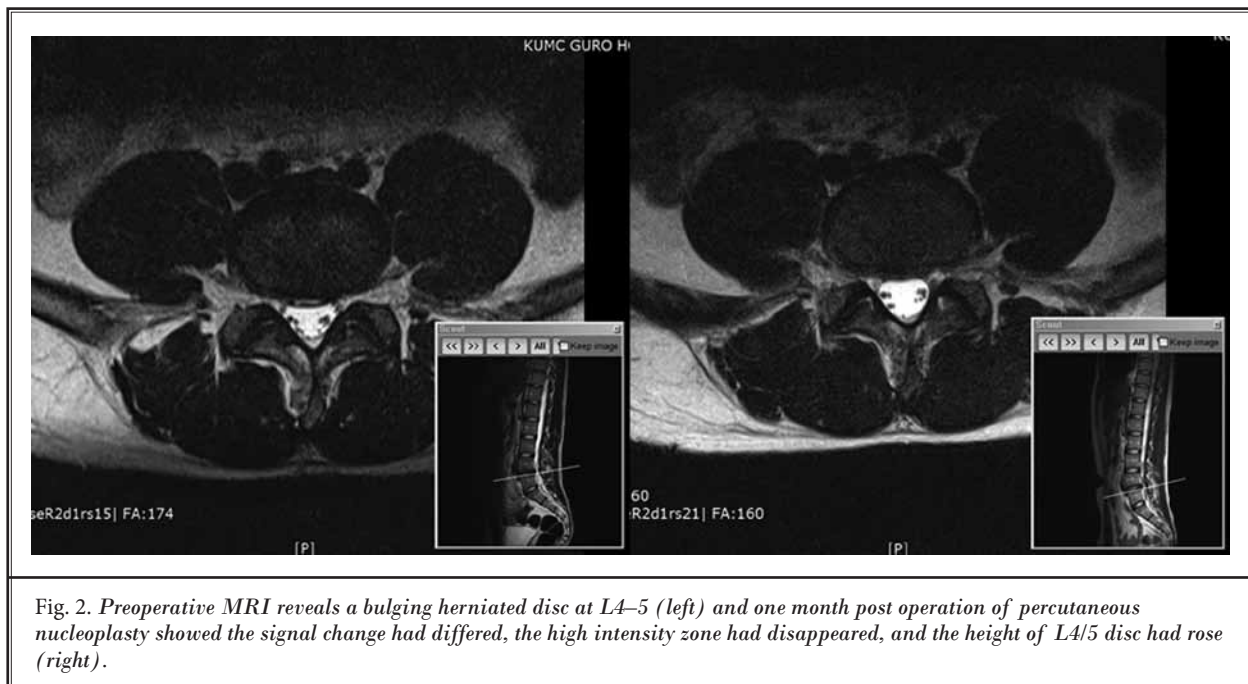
Preoperative MRI reveals a bulging herniated disc at L4–5 (left) and one month post operation of percutaneous nucleoplasty showed the signal change had differed, the high intensity zone had disappeared, and the height of L4/5 disc had rose (right).
